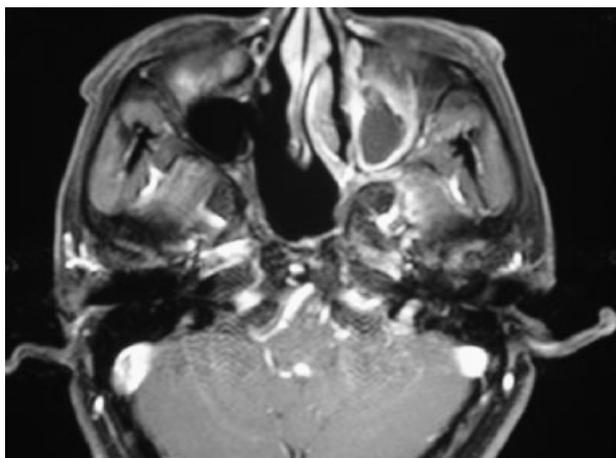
The axial view of the T1-weighted MRI with Gadolinium enhancement done 3 years after treatment shows no abnormal tumor lesion in the nasopharynx.
